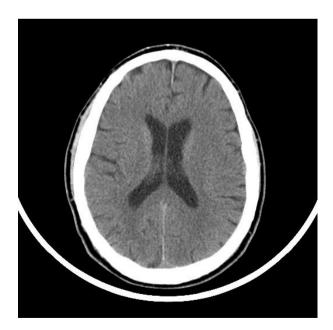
CT scan taken at the onset of symptoms failing to show any abnormalities.
